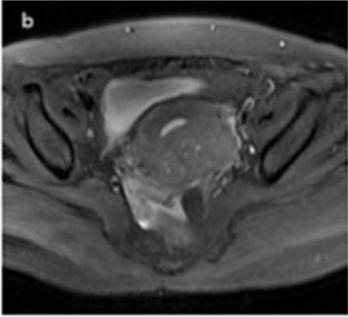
b: The Axial fat-suppressed T2-weighted imaging
